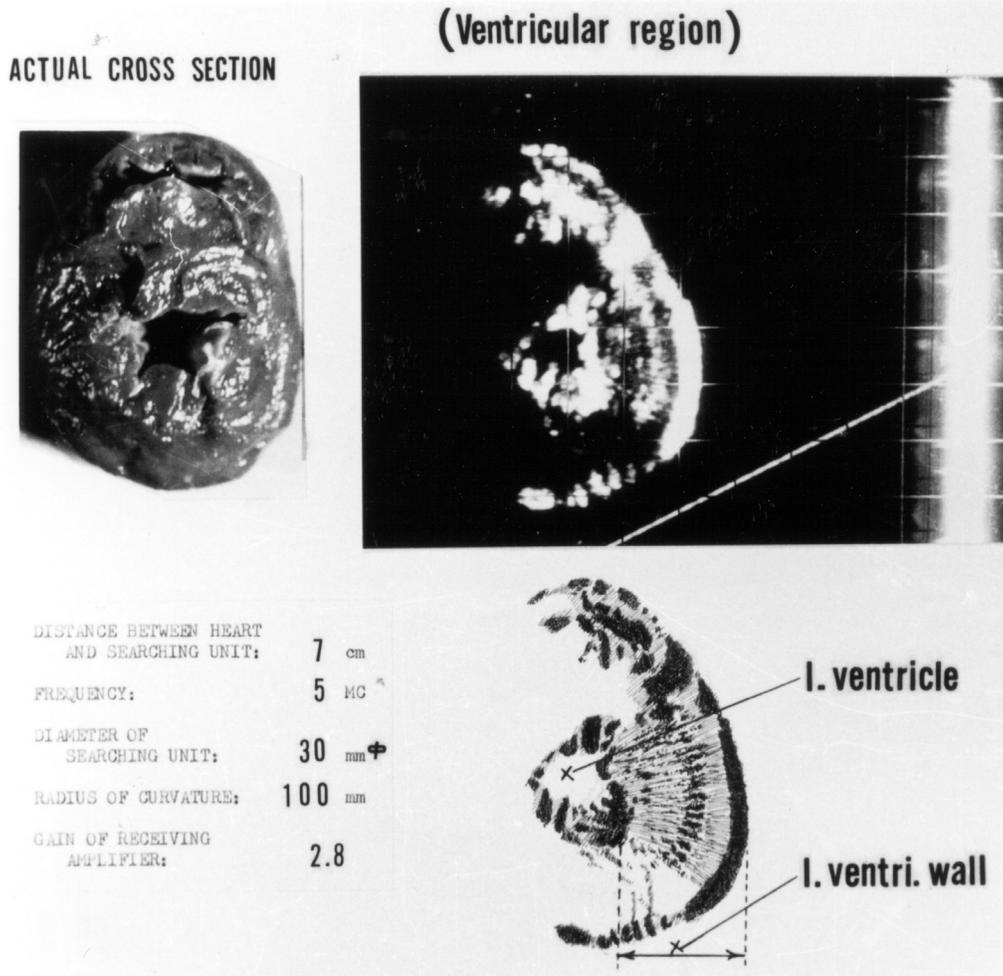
High quality ultrasono-cardiotomogram (2-dimensional echocardiogram) of a canine heart at the left ventricular level obtained by using a concave disk transducer of 30 mm diameter, 100 mm radius of curvature, and 5-MHZ frequency. The heart just after excision was suspended at the focal area in the water bath. The echo pattern shows the three-layer structure.
